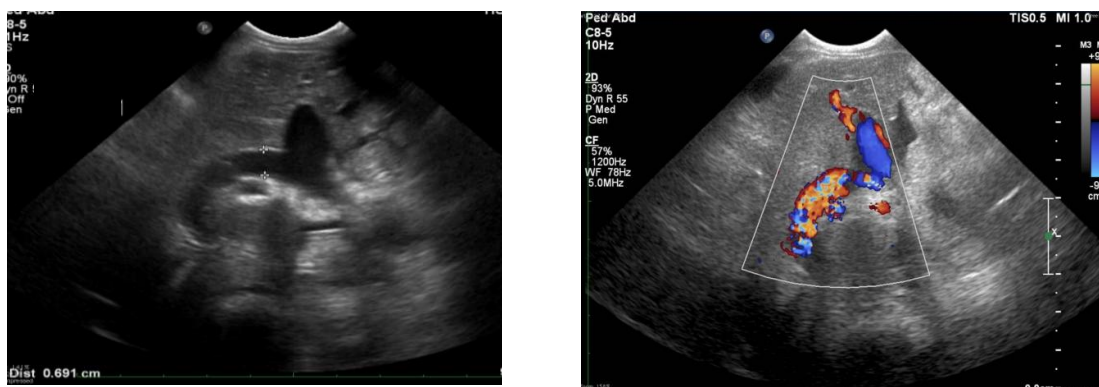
B mode and Color Doppler ultrasound of the liver shows a large tortuous portal vessel (measure 0.69cm in diameter) with turbulent flow.
